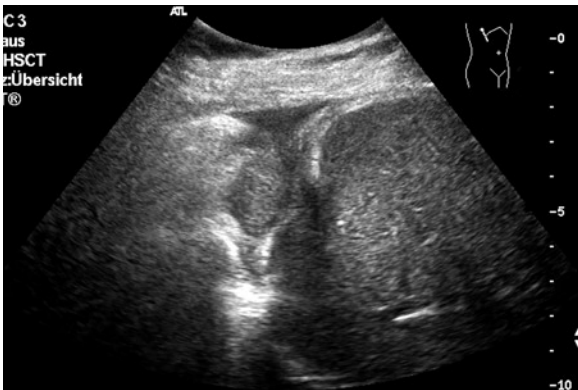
Sonomorphologically similar finding to that in Fig. 3.50 in a patient with known bronchial carcinoma without any known metastases up to that day. The finding was detected during a routine abdominal sonography. The finding was not comprehensible on computed tomography. An ultrasound-guided biopsy confirmed the clinical suspicion of metastasis of the known bronchogenic carcinoma
